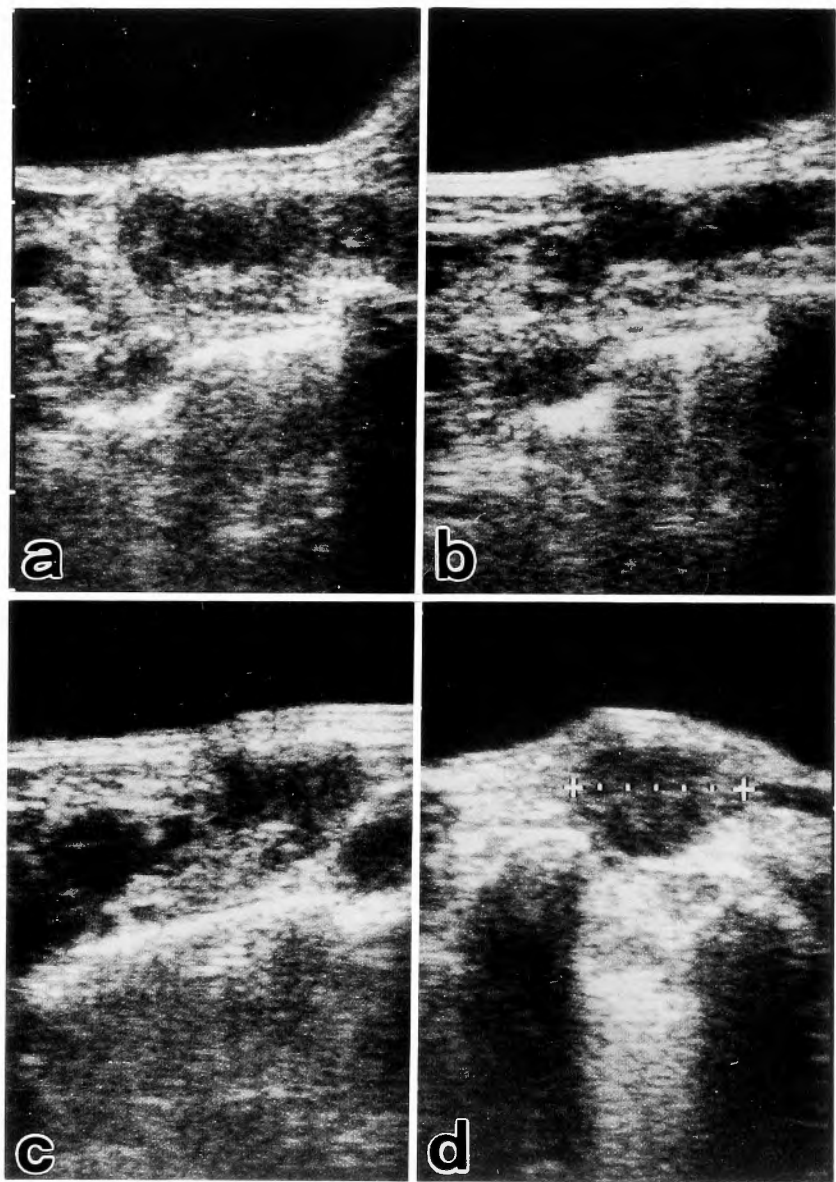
Ultrasonograms of two masses consisted of conglomerate lymph nodes in the medial supraclavicular region (a, b) and lymph nodes in the lateral supraclavicular region (c, d)
